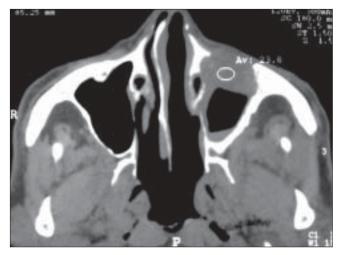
Craneal CT reveals infiltrating lesion with rupture of maxillary antrum
